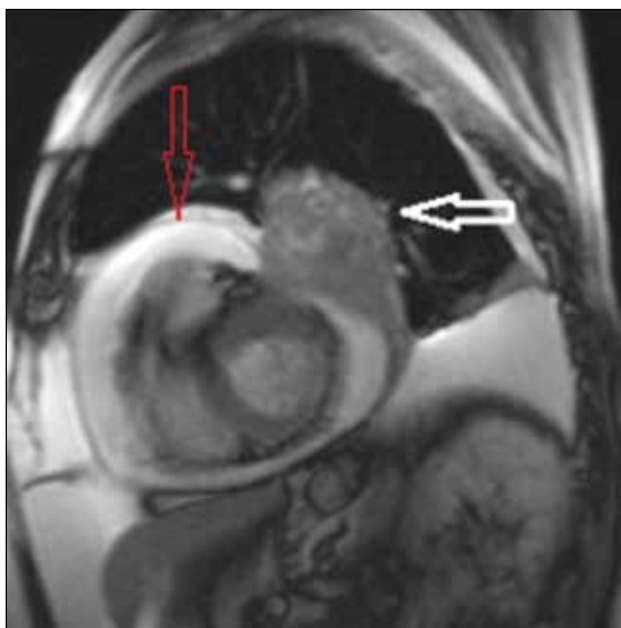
Cardiac magnetic resonance image of a 67-year-old male patient who presented with a cough that had lasted for >6 months. Computed tomography of the thorax showed a central lung mass (not shown) invading the heart. The image depicted the lesion (white arrow) and its extension through the pericardium and myocardium. A pericardial effusion, most probably due to the tumoural involvement, was also noted (red arrow).
